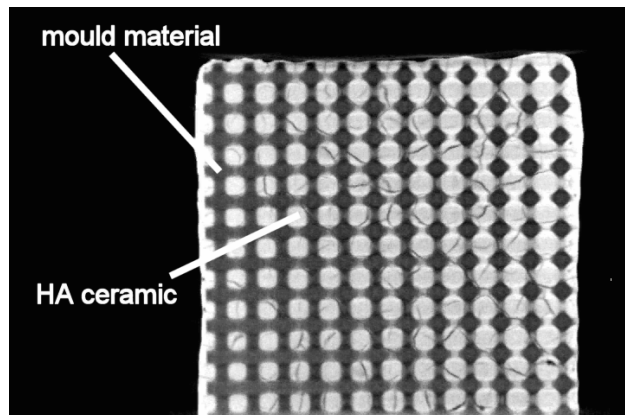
Mikro CT of an impregnated mold
